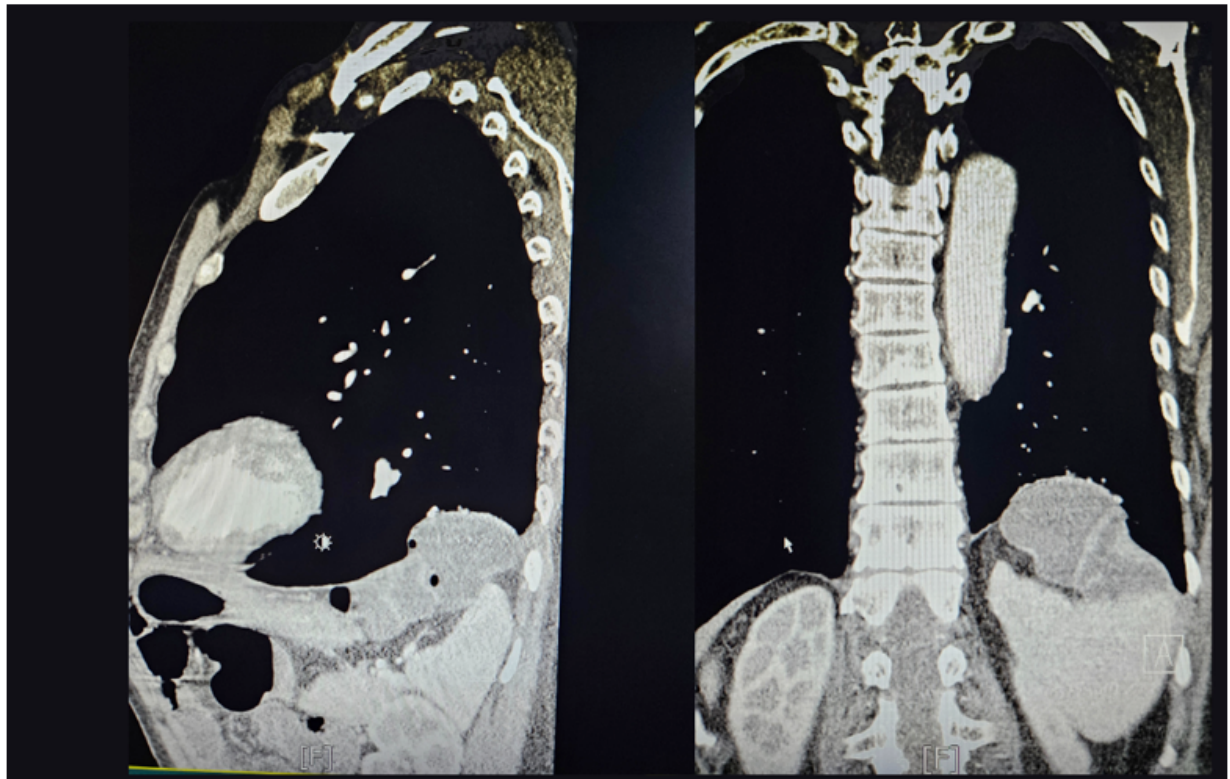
Sagittal und coronal CT scan showing a posterior defect at the left hemidiaphragm, 75 x 68 mm hernial orifice with herniation of the left colic flexure.
